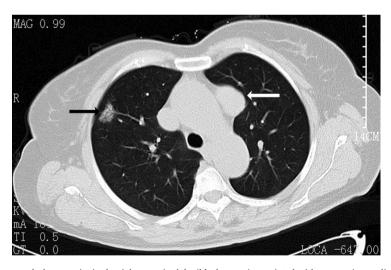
CT-scan of the chest showing a ground-glass opacity in the right superior lobe (black arrow) associated with an anterior mediastinal solid lesion (white arrow).
